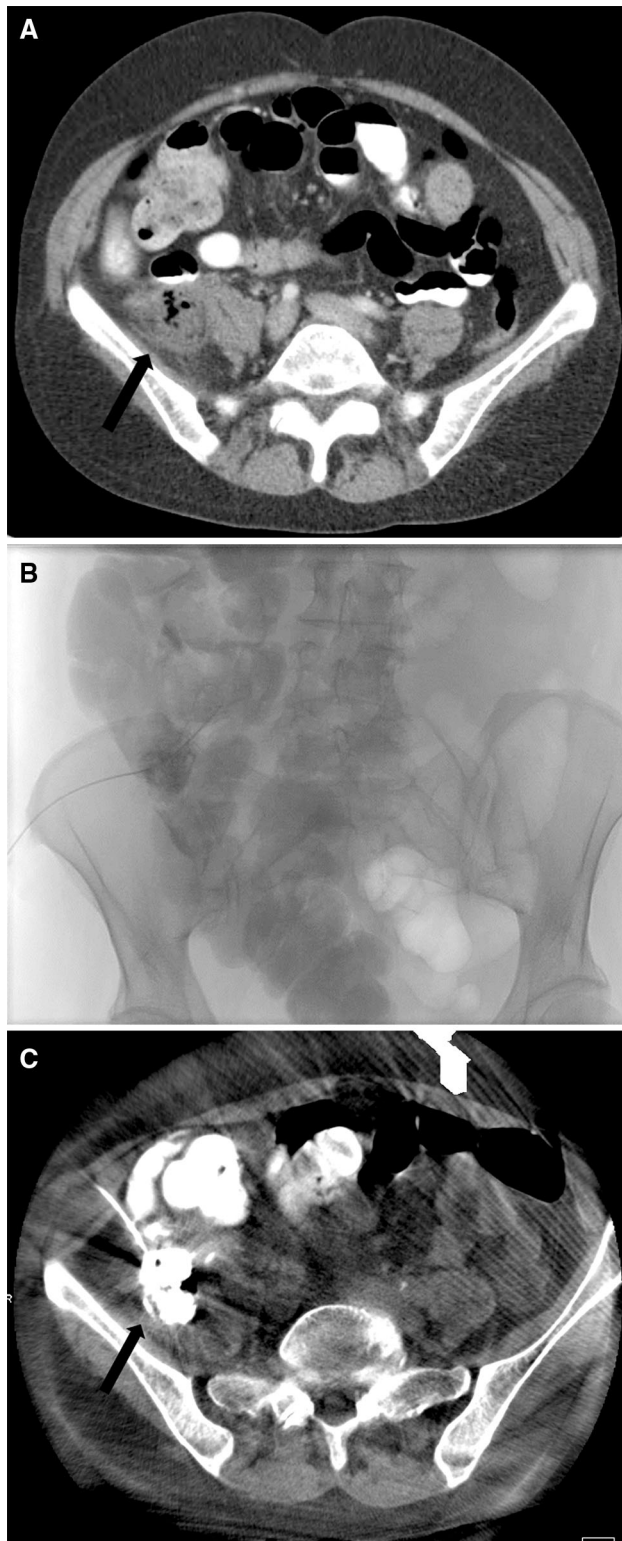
A 55-year-old woman presents with a periappendiceal abscess. A Contrast-enhanced axial CT image shows acute appendicitis with periappendiceal abscess (*arrow*). B Anteroposterior fluoroscopic image obtained during percutaneous drainage shows a 5-French catheter and guidewire within the right lower quadrant. Contrast is injected into the periappendiceal abscess cavity; however, contrast-opacified bowel has a similar appearance. C Axial C-arm flat detector computed tomography image of the pelvis demonstrates appropriate placement of the 5-French catheter (*arrow*) into the contrast-opacified periappendiceal abscess cavity. The catheter tract is subsequently dilated with successful placement of a 10-French Dawson–Mueller catheter
